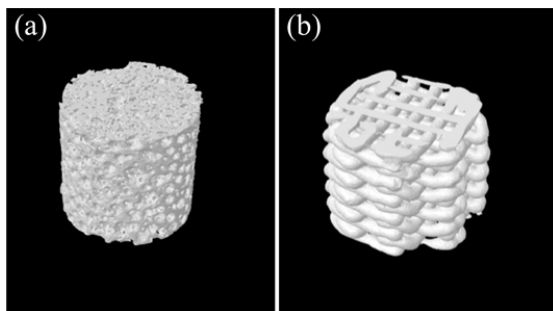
μ CT 3D images of one foamed (a) and one robocast (b) scaffold. The diameter of the scaffolds is approximately 5 mm. The full height of the samples is 10 mm, here approximately half the height is shown.
